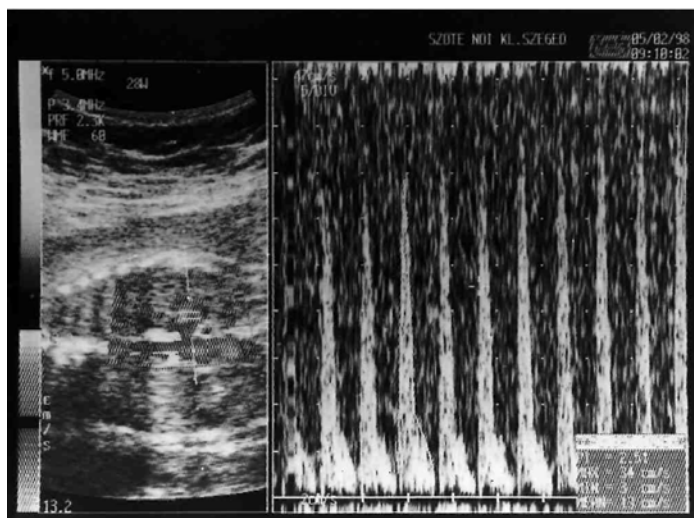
Decreased blood flow-velocity waveforms in the renal artery at 32nd week of gestation. The Doppler gate is positioned over the main renal artery
